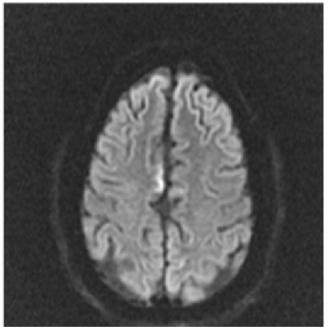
Brain MRI in adult patient diagnosticated with MELAS Syndrome. 24 years old woman with confirmed mA3243G mutation and classical MELAS syndrome. Diffusion weighted brain MRI images show two SLE. A: right temporoparietal cortical hyperintensity corresponding to first SLE; B: the same patient, hospitalized two weeks after by another SLE, image shows cortical hyperintensity in the medial right frontal region. The previous lesion is not visible.
